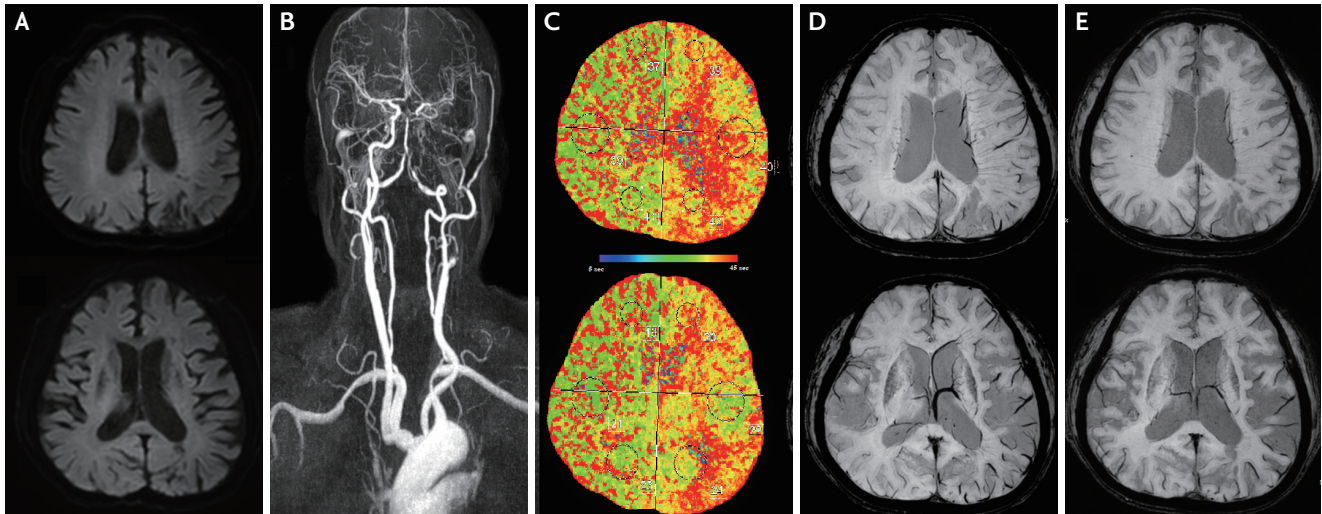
(A-D) Initial and (E) follow-up images. (A) Axial diffusion-weighted image and (B) angiography image revealing collateral flow (C) with a prolonged mean transit time (computed tomography perfusion image). (D) Initial and (E) follow up (5 hours later), susceptibility-weighted imaging scans showing dynamically reduced prominent vessel sign in the cortical, medullary, and thalamostriate vein in the left hemisphere.
